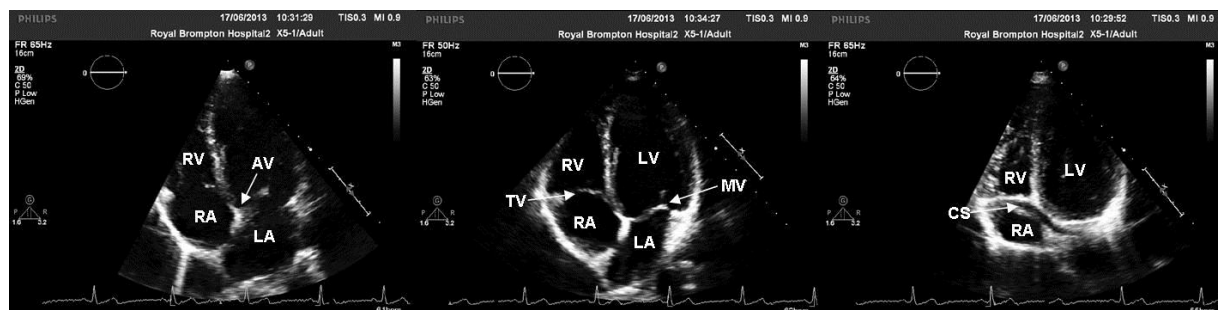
Apical four-chamber views showing the effect of tilting the ultrasound beam. In the centre is an optimal four-chamber view. On the image to the left the US beam has been tilted superiorly, opening up the aortic valve (AV) which is seen at the centre of the heart. On the image to the right, the US beam is tilted too inferiorly, bringing the coronary sinus (CS) into view – seen as a linear black structure as it drains blood into the RA. The LA is foreshortened and not seen in this image.
